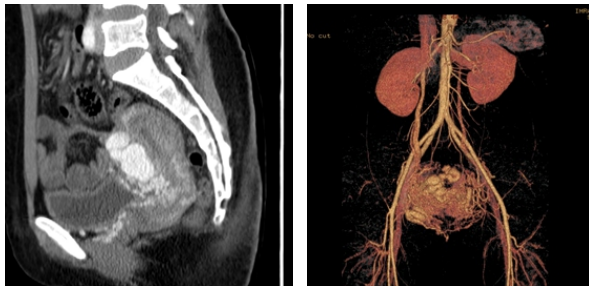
(Left) Post contrast Arterial phase sagittal CT image & (Right) Volume Rendering Reconstruction - dilated vascular channels filled with contrast material with predominant blood supply from iliac artery.
